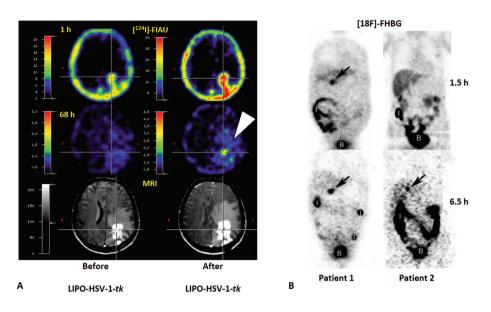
HSV1-tk reporter gene imaging in patients after Liposome-HSV-1-tk-complex transduction (A). Coregistration of [1241]FIAU-PET and MRI before (left column) and after (right column) HSV1-tk vector application. A region of specific [1241]FIAU retention (at 68 h) within the tumor is visualized (white arrow). This tumor region showed signs of necrosis (cross hairs, right column after ganciclovir treatment. Figure adapted from Jacobs et al. (2001) [100].
